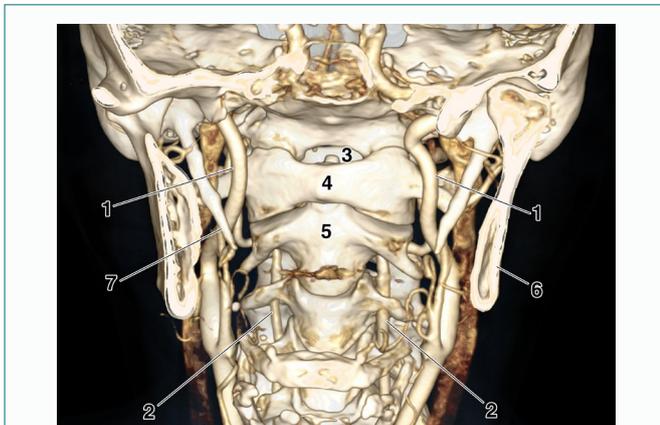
A coronal section of a 3D CTA image of the cervical arteries in a healthy individual. Note the right and left internal carotid arteries (1), and the right and left vertebral arteries (2). 3 – the foramen magnum; 4 – the atlas; 5 – the axis; 6 – the mandible; 7 – the styloid process.
